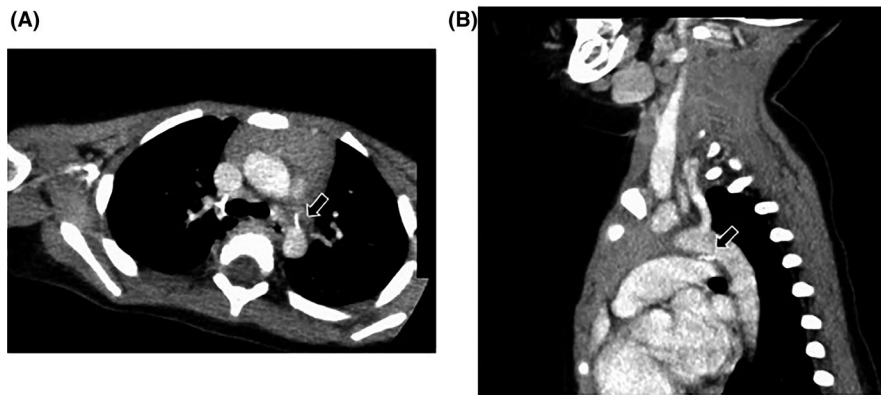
Horizontal (A) and sagittal (B) sections of chest contrast-enhanced computed tomography revealing a linear structure on the outside of the esophagus at the sagittal section near the vicinity of the ligamentum arteriosum closure. Black arrow; calcified structure
